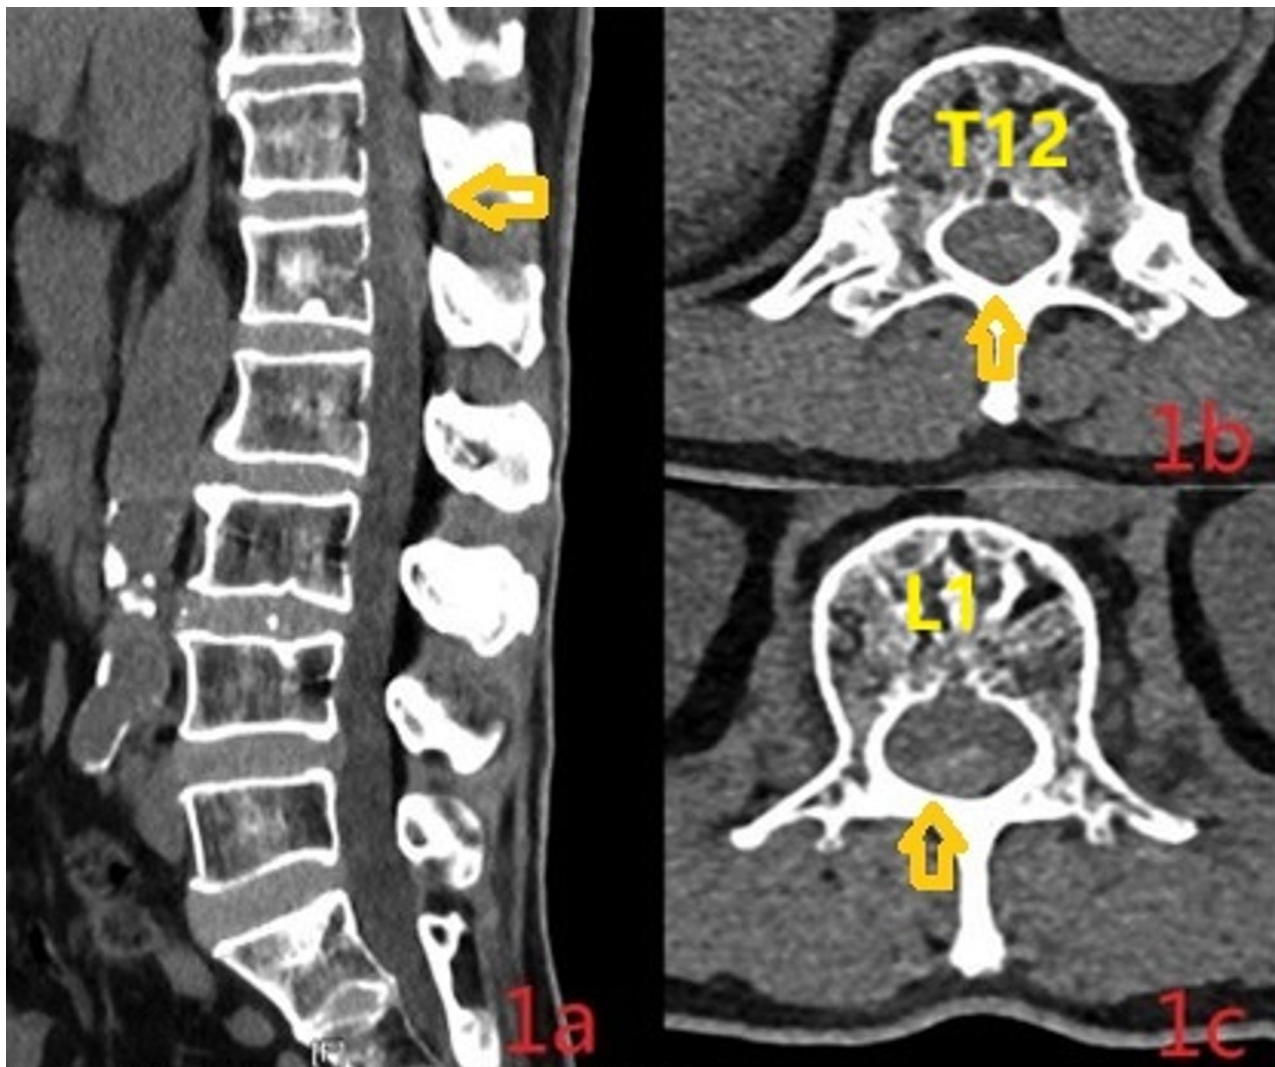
Lumbar computer tomography imaging without contrast (on the day of symptom onset), arrow: epidural hematoma at the T11-L1 levels occupies the spinal canal and compresses the spinal cord. 1a: A band-like soft tissue density is observed posterior to the spinal canal at the T11-L1 level, the average reference CT value was approximately 69 HU. 1b: A soft tissue density lesion is identified dorsally within the spinal canal at the T12 level, resulting in a reduction of the effective spinal canal volume, and demonstrating a well-defined margin with the adjacent dural sac. 1c: A soft tissue density lesion is identified dorsally within the spinal canal at the L1 level, its extent is observed to be smaller compared to that at the T12 level
